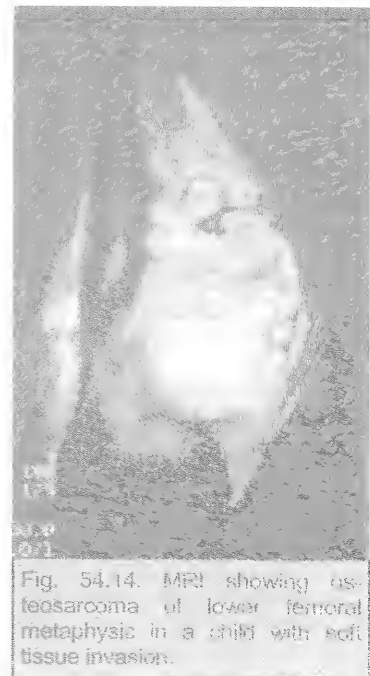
MRI showing osteosarcoma of lower femoral metaphysis in a child with soft tissue invasion.
